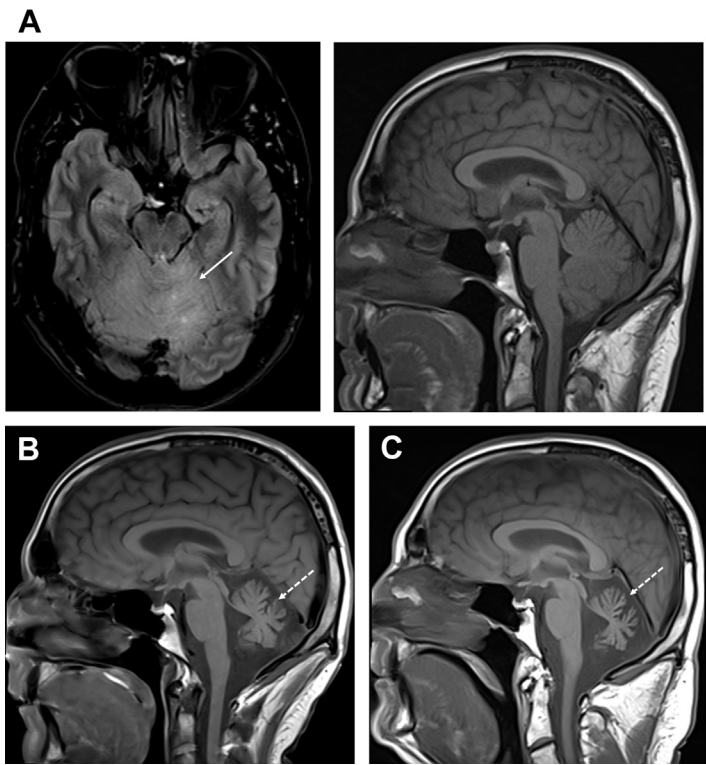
PCD in a 56-year-old patient with adenocarcinomas of colon. Axial FLAIR and sagittal T1WIs (2014 [A]) show subtle superior cerebellar hyperintensity on FLAIR image (arrow) with normal volume. Sagittal T1WIs (MRI in 2017 [B] and MRI in 2019 [C]) show progressive global volume loss in both the vermis and cerebellar hemispheres (arrows in Band C).
